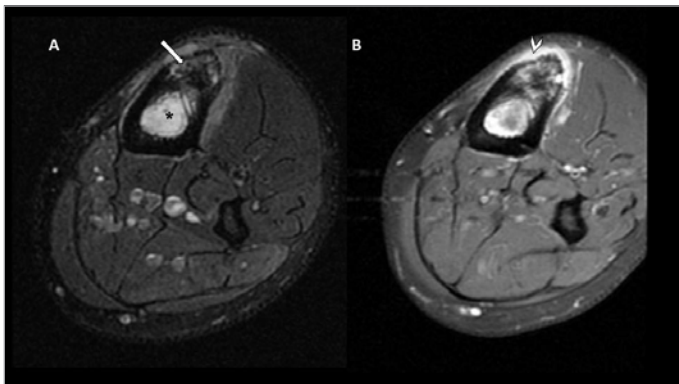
Paget's disease MRI.
